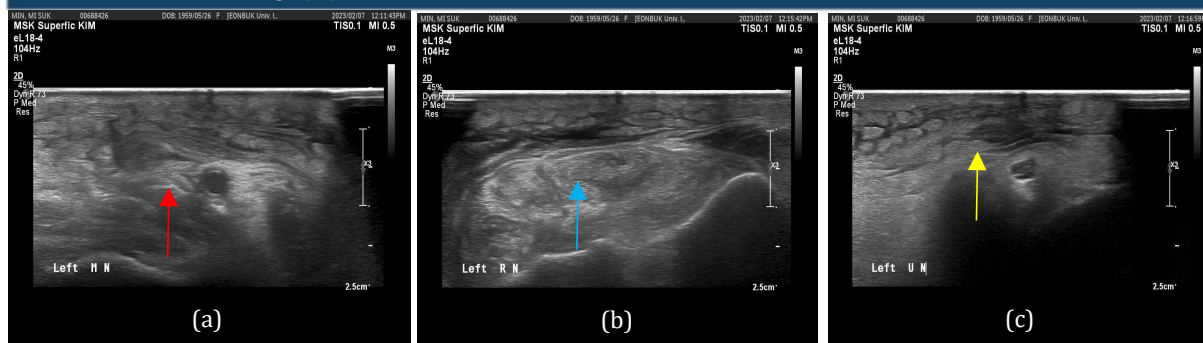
Ultrasound image. (a) left median nerve (red solid arrow), (b) left radial nerve (blue solid arrow), (c) left ulnar nerve (yellow solid arrow).
